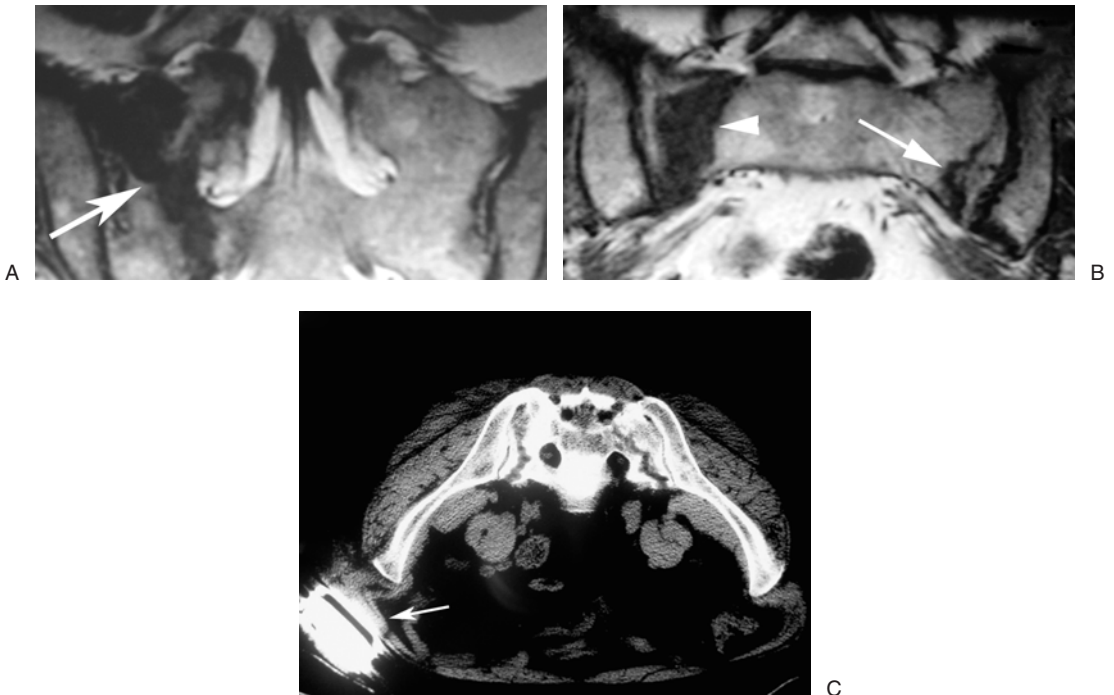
(A) Coronal T1 MR image shows the initial presenting sacral fracture that involves only one sacral wing (white arrow). (B) The same patient 2 months later has a repeat scan that now reveals another fracture extending into the opposite sacral wing (white arrow). The initial fracture (white arrowhead) is still seen. (C) A CT scan at the time of treatment with PS demonstrates the bilateral sacral wing fractures. Note that the patient has a pain pump (white arrow) in place and has had disabling pain throughout the course of this 6-month period.
